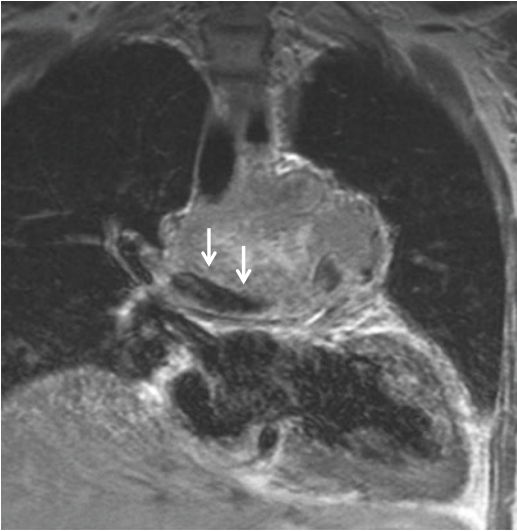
Neuroendocrine tumor. Contrast-enhanced coronal MR image shows a lobulated mass displacing the pulmonary artery (arrows)
